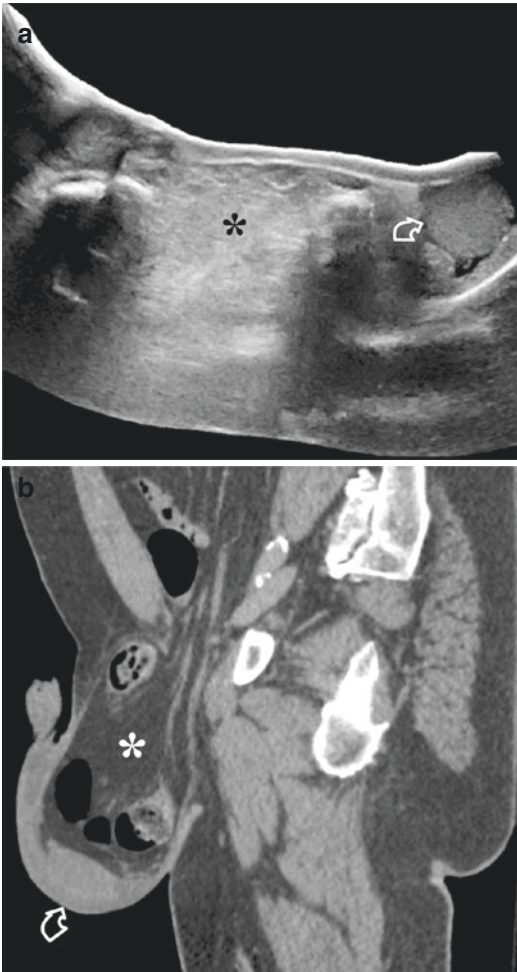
(a) Inguinoscrotal hernia. Panoramic ultrasonographic view showing a bowel loop containing air (*asterisk*) within the scrotum. The testis (*curved arrow*) is normal. (b) Sagittal CT scan confirms scrotal herniation of a bowel loop (*asterisk*). The testis is normal (*curved arrow*)
